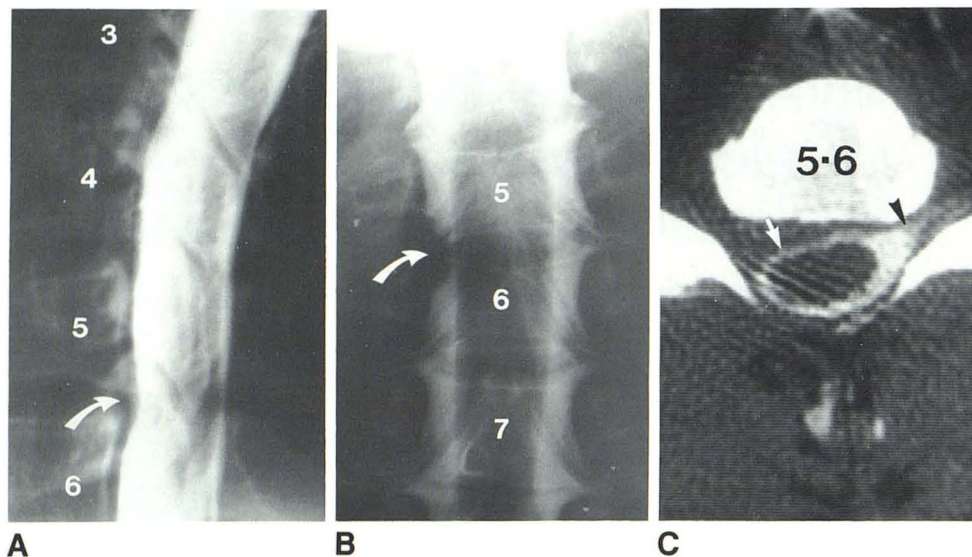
29-year-old man with right C6 radiculopathy. A, Lateral myelogram. Minimal ventral extradural defect at C5–C6 (arrow). B, Anteroposterior spot film. Right C6 root sleeve cutoff (arrow). C, Axial CT myelogram. Normal filling of left C6 root sleeve (arrowhead) with nonfilling of right C6 nerve root secondary to soft (nonossified) lateral disk herniation. Rotation of cord to left with attenuation of ventral subarachnoid space (arrow). Herniated disk was removed via C5–C6 anterior discectomy. Patient had complete resolution of radiculopathy.
